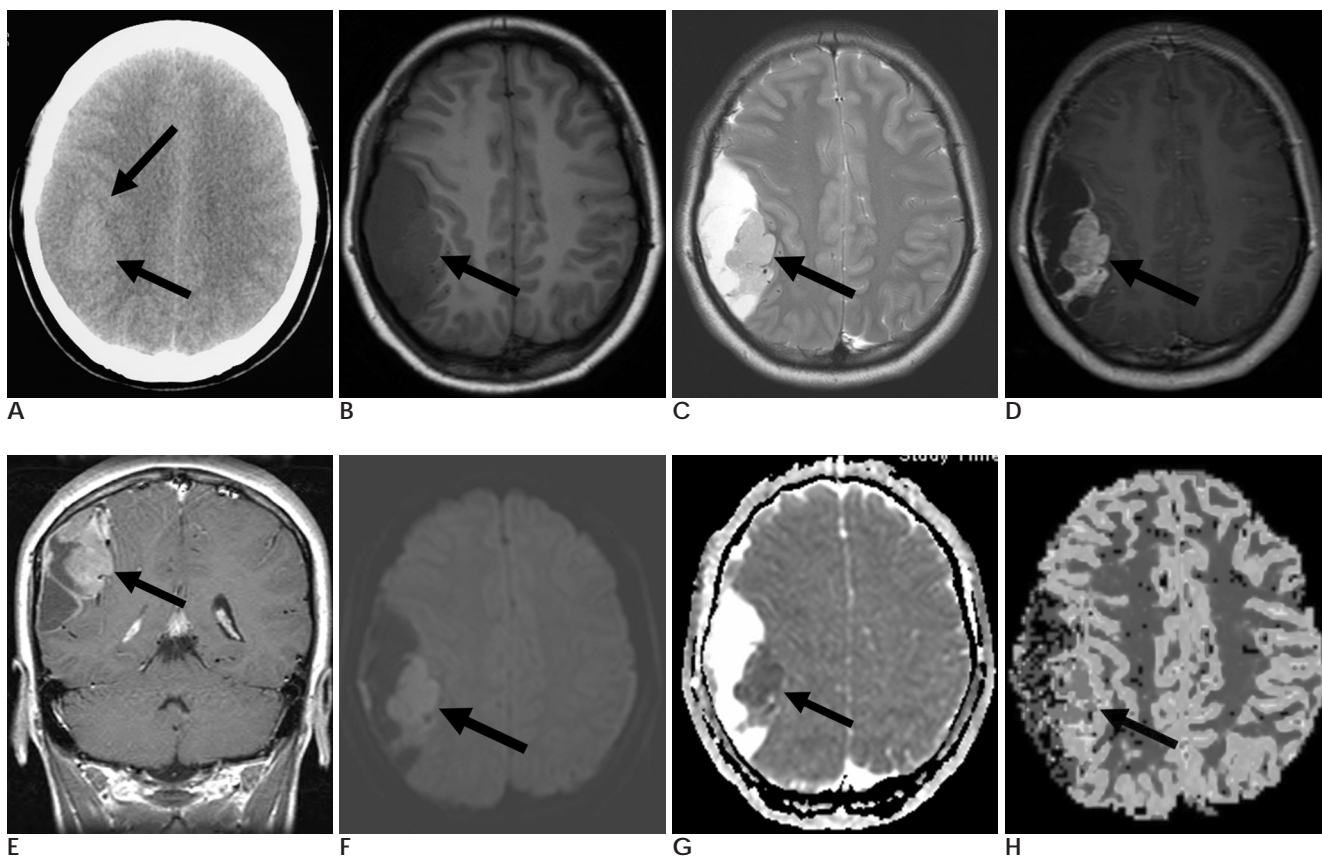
A. Axial unenhanced CT scan of the brain shows a space-occupying lesion at the right frontoparietal convexity (arrows). B. Axial T1-weighted image shows the solid portion of the mass isointense to the gray matter (arrow). C. Axial T2-weighted image clearly shows the tumor consisting of two parts. The solid portion of the tumor is isointense or slight hyperintense to the gray matter (arrow). D, E. Axial (D) and coronal (E) gadolinium-enhanced T1-weighted images show moderate enhancement of the tumor with unenhancing cystic portion (arrow). F, G. The solid portion of the tumor is slightly hyperintense to the gray matter on diffusion-weighted image with restriction of diffusion on ADC map (arrow). H. Perfusion-weighted MR image shows increased cerebral blood volume in the solid part of tumor (arrow).
